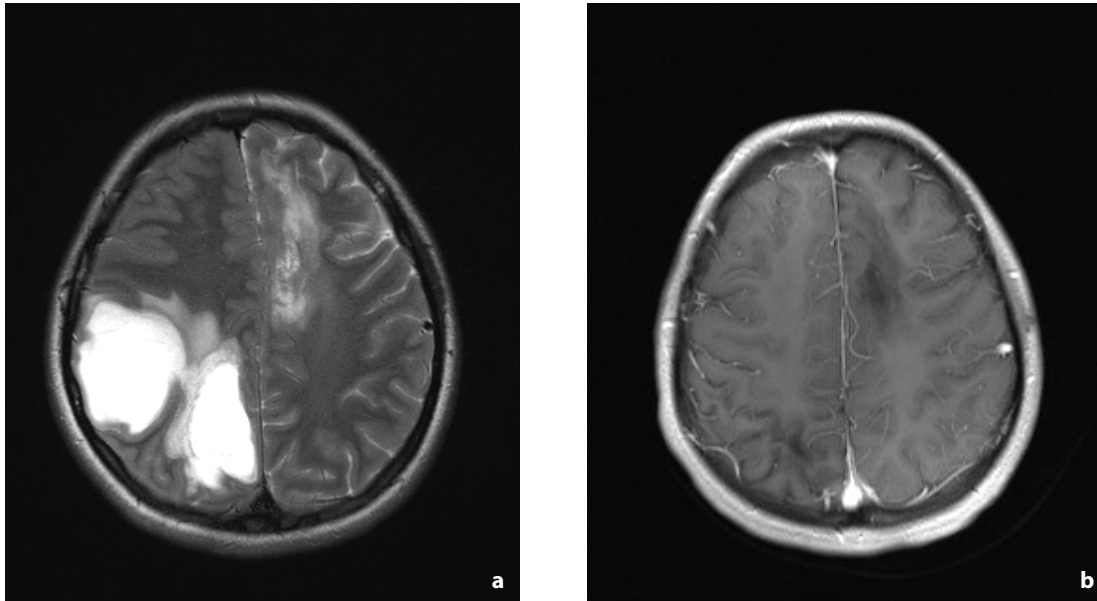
a) Brain MRI showing further evolution of the tumefactive lesions (T2 axial). b) Brain MRI showing resolution of multiple lesions (T2 axial).
